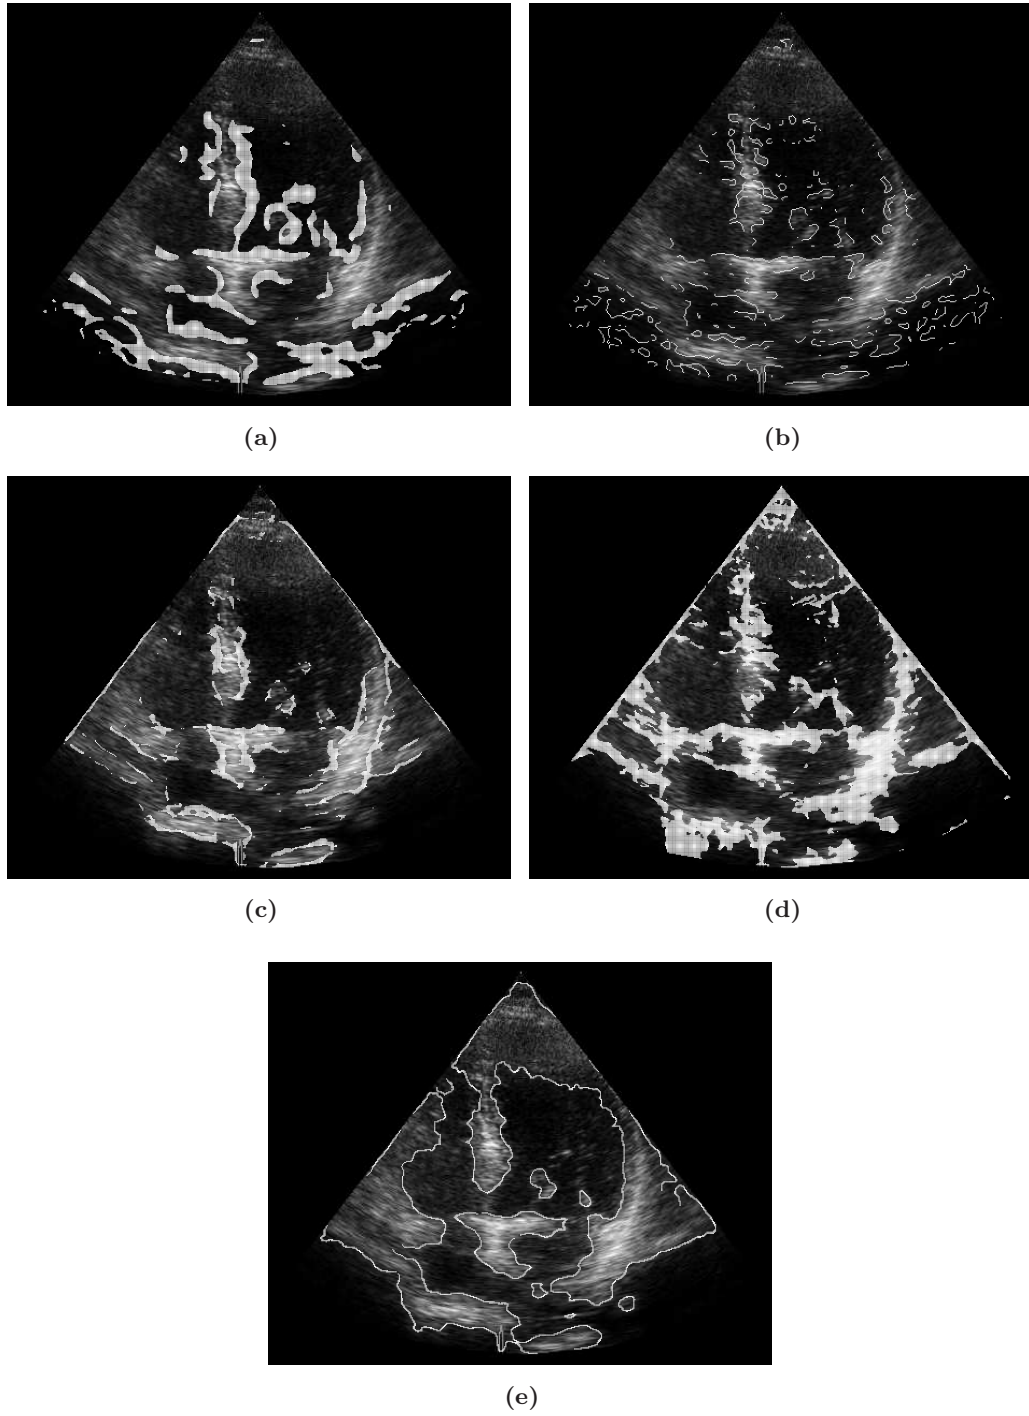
Edge detector output for the clinical ultrasound images of Fig. 6.8(c). (a) CV, (b) RoA, (c) FA, (d) PC, (e) ZC.
